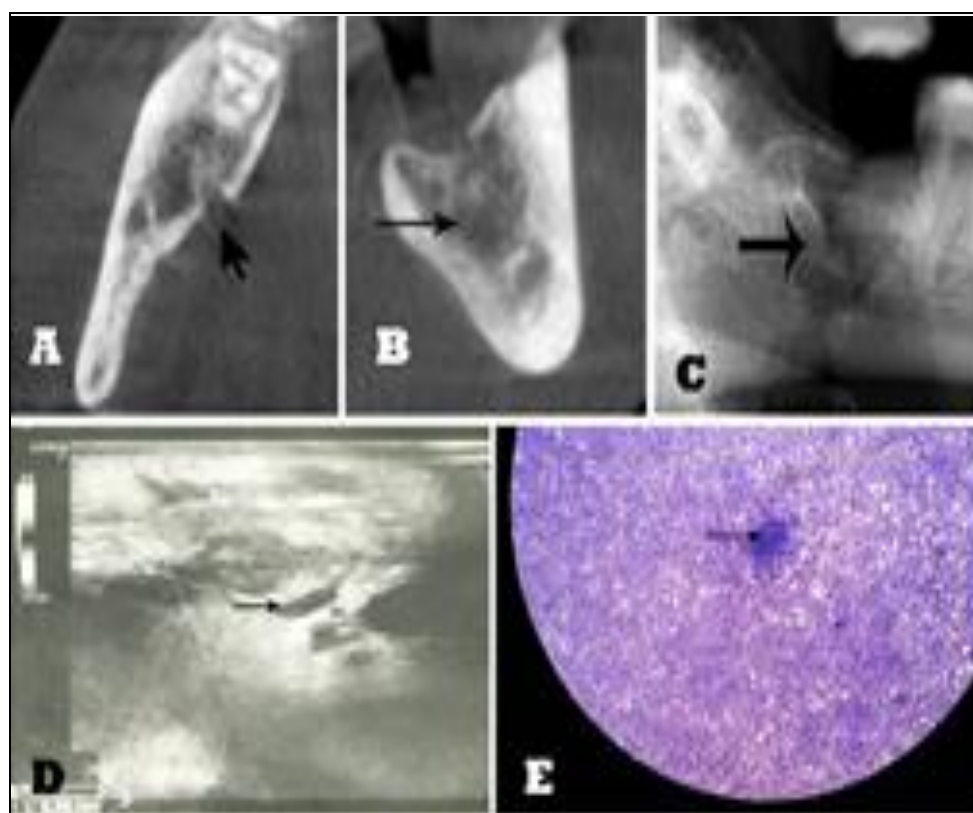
3B, 3C, 3D & 3E. 3A. Axial Section CBCT Showing Mixed Density Lesion and Lingual Cortical Breach (Arrow). 3B. Coronal Section CBCT Showing Mixed Density Lesion (Arrow) with Defined Sclerosing Periphery. 3C. 2D Tomographic View Showing Disruption of the Cortex. 3D. US Image Showing Circular Hypoechoic Area in Right Submandibular Gland with Multiple Echogenic Foci (Arrow) & Oedematous Changes Skin and Subcutaneous Tissue. 3E. FNAC Demonstrated Few Colonies of Actinomycosis (Arrow) against the Background of Haemorrhage and Neutrophils.
